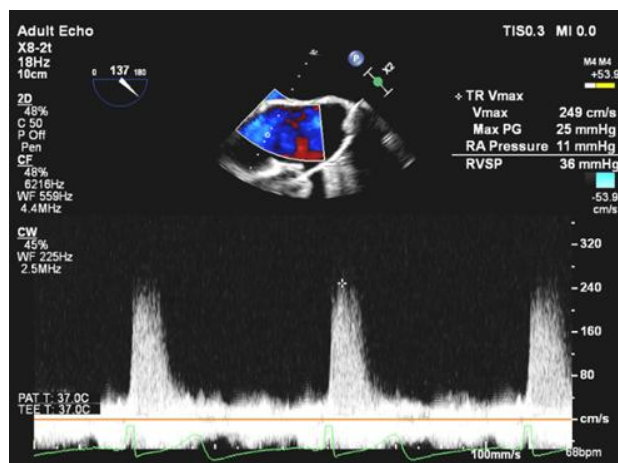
Continuous wave Doppler measuring tricuspid regurgitation velocity, obtained in the mid esophageal modified bicaval view.
